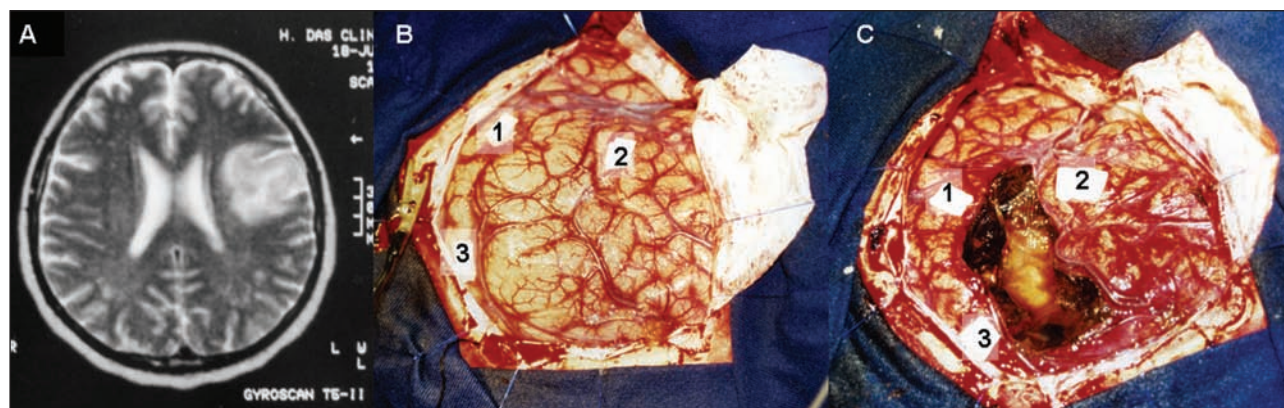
(A) Patient with close tumoral lesion to the motor and speech area evidenced by MRI (B) Intraoperative field showing the lesion adjacent to the eloquent cortex with probably infiltration. Cortical stimulation revealed two speech areas (1 and 2) and the motor gyrus (3). (C) After resection the tumor. At the end of surgery the patient had motor aphasia and there was no sign of movements in contralateral hand. He did not recover the deficits.
